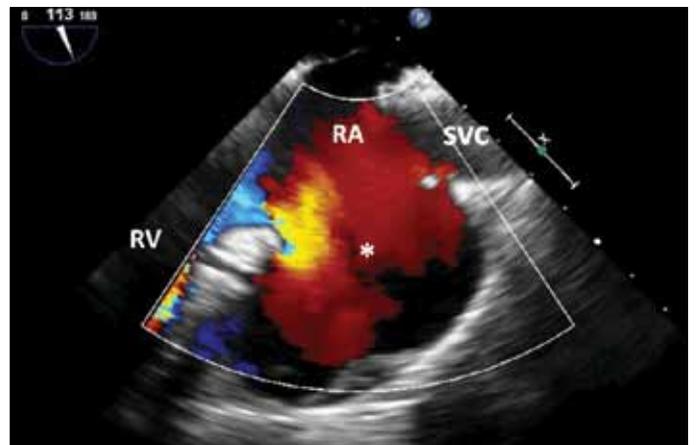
Transesophageal echocardiography in the 113° view revealed a giant right atrial appendage aneurysm
